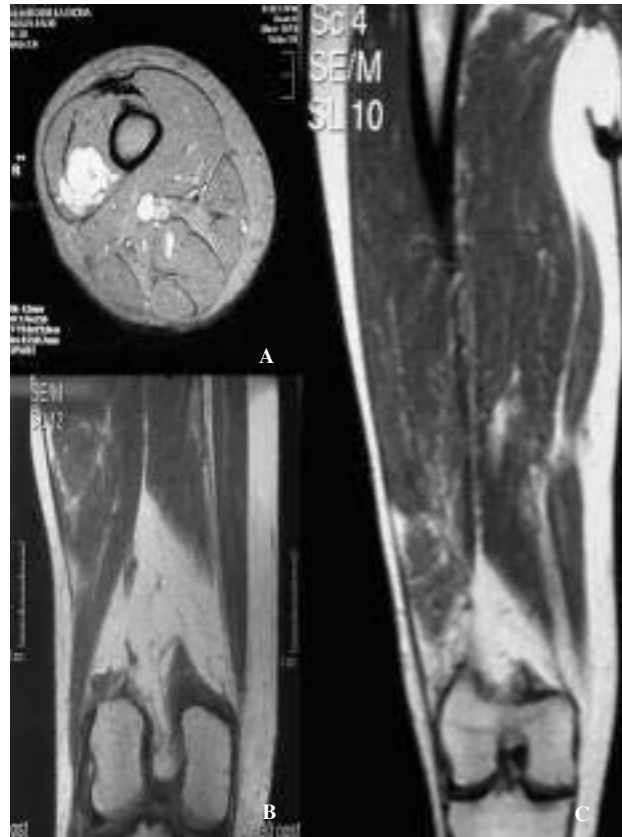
Nuclear Magnetic Resonance views of the lower third of the right thigh. (A) T2-weighted axial slice showing a hyperintense tumoral mass in the vastus lateralis muscle. (B) and (C) T1-weighted coronal slices showing a tumoral mass that is virtually isointense with respect to the surrounding muscles; there is hyperintense reinforcement in the tumoral periphery.
